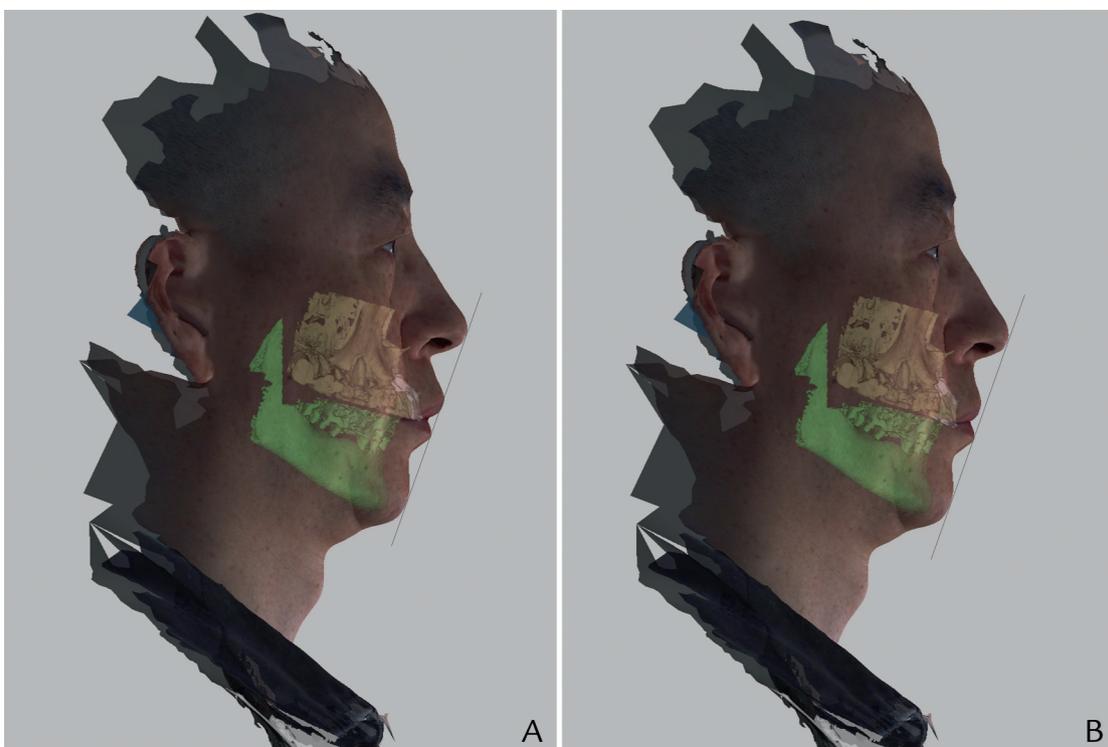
A, Infusion of CBCT scan with 3D facial image in Dolphin software. B, Prediction of lateral profile with 3.0-mm retraction of anterior teeth. CBCT, cone beam computed tomography.
